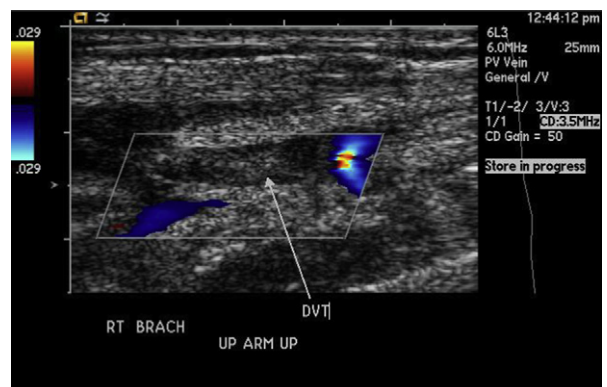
Color Doppler duplex ultrasonography demonstrates right brachial vein deep venous thrombosis (DVT).
